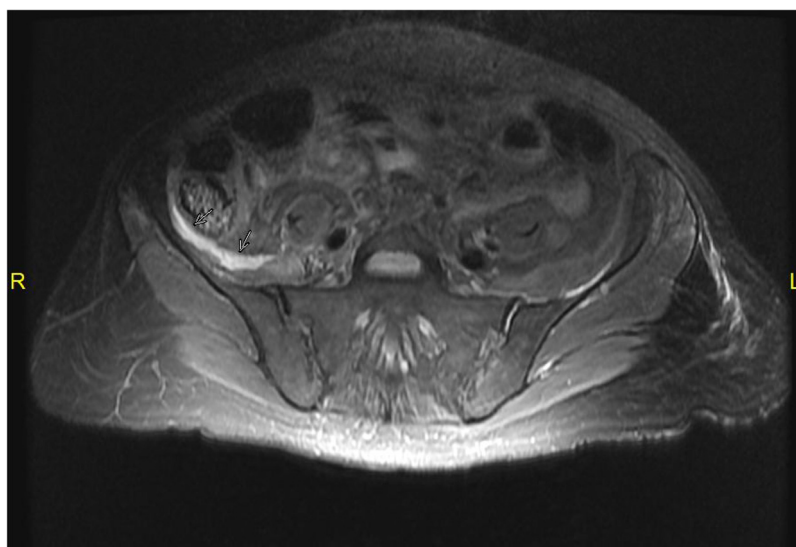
Post-operative MRI, day 14, showing large fluid collection (marked by two solid arrows) overlying the right iliacus muscle.
